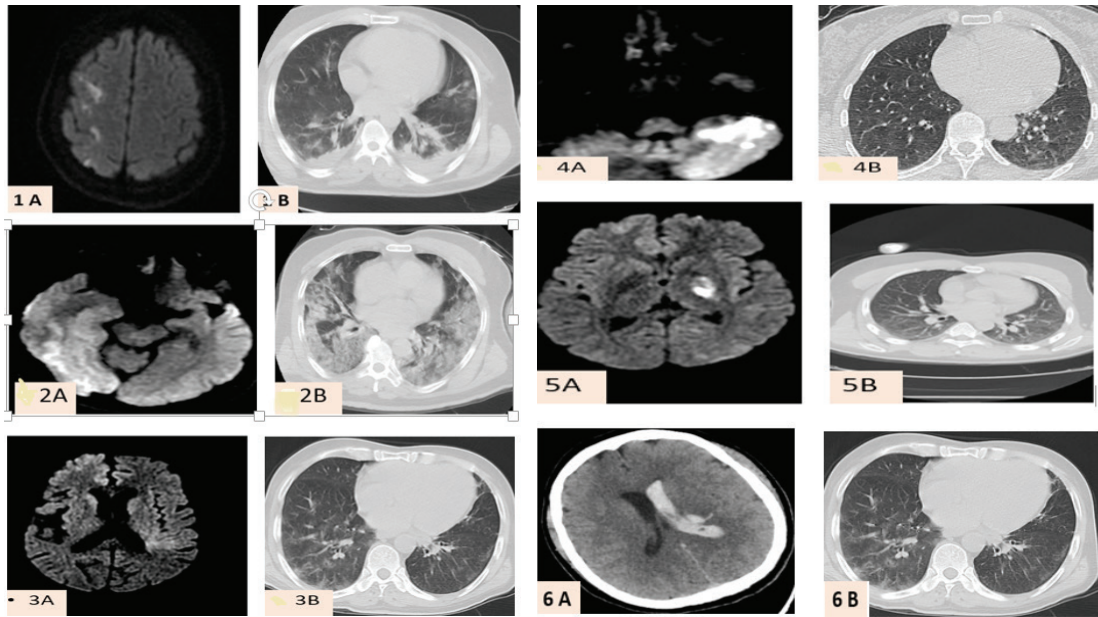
Brain diffusion MRI, and lung CT scans of patients.
